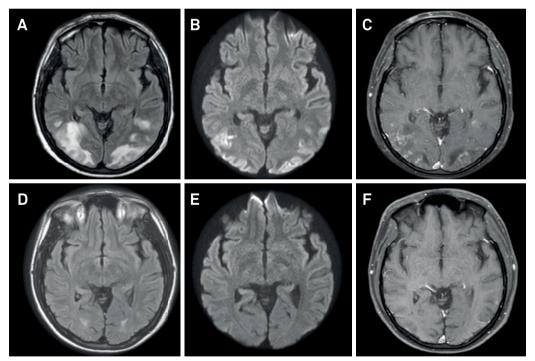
MRI showed cortical and subcortical FLAIR hyperintense signals involving the occipital lobes (A), with restricted diffusion (B) and contrast enhancement (C). The findings of diffusion restriction and contrast enhancement are more severe imaging findings and are described as factors of a worse prognosis and partial recovery in PRES. After TCZ withdrawal, the patient's imaging findings improved (D, E, and F), with partial recovery of the visual symptoms.
